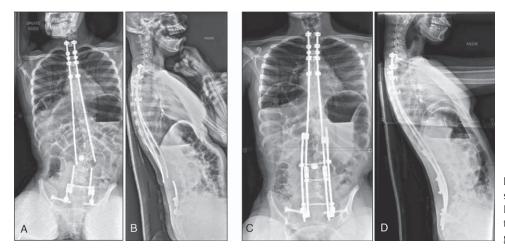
Nonambulatory 14-year-old girl suffering from dystonic cerebral palsy. (A/B) x-ray of rod fracture 4.5 years after initial surgery; (C/D) x-ray after revision surgery and additional rod implantation.
